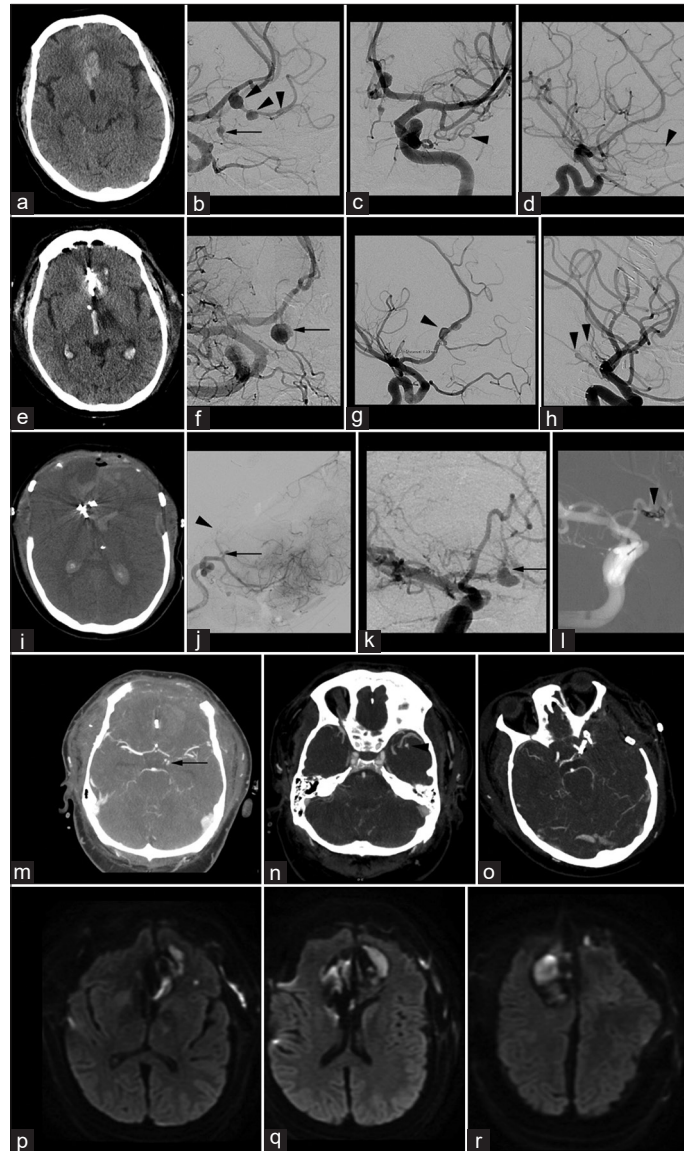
Depiction of the most relevant imaging findings from the patient's treatment. (a) Presentation CT head demonstrating left inferior frontal hemorrhage suspicious of vascular origin, (b-d) initial diagnostic DSA, (b) lateral view of the left ICA injection demonstrating $\times 1$ fusiform aneurysm on the orbitofrontal branch of the left ACA (arrow) and 3 fusiform aneurysms on the frontopolar branch of the left ACA (arrowheads), (c) AP view of the left ICA injection demonstrating fusiform aneurysm at the distal ATA of the left MCA (arrowhead), (d) lateral view of the right ICA injection demonstrating a fusiform aneurysm on the frontopolar branch of the right ACA (arrowhead), (e) CT scan obtained on postbleed day 4 and postoperative day 2 following parent vessel occlusion of the left frontopolar branch of the left ACA demonstrating new IVH and fresh blood in the inferior left frontal lobe suggesting re-bleed, (f-h) DSA obtained following re-bleeding on postbleed day 4, (f) oblique view of the left ICA injection demonstrating interval growth of the untreated left orbitofrontal branch fusiform aneurysm (arrow), (g) lateral view of the right ICA injection showing three new fusiform aneurysms on the A2 segment of the right ACA (arrowhead), (h) AP view of the left ICA injection showing new fusiform aneurysms of the distal AChA and PCOMA (arrowheads), (i and j) postbleed day 8 following further surgery with bilateral A2 occlusion and bifrontal decompression, (i) CT head demonstrating extensive bifrontal decompression and swelling following intraoperative sacrifice of bilateral A2s, (j) intraoperative DSA demonstrating no flow in the left ACA at the A2 segment (arrowhead) with new aneurysm formation at the ACOMA (arrow), (k-l) interval DSA on postbleed day 9, (k) AP injection of the right ICA demonstrating treating growth of the ACOMA aneurysm (arrow), (l) intraprocedural image on postbleed day 9 during parent vessel occlusion of the right A1 to treat the enlarging ACOMA aneurysm (arrowhead), (m) Interval imaging on postbleed day 10 demonstrating growth of the previously identified AChA and PCOMA aneurysms (arrow), (n) interval imaging on postbleed day 10 demonstrating stable ATA aneurysm, (o) postoperative CT head following pterional craniotomy and parent vessel occlusion of the growing AChA and PCOMA aneurysms and the stable ATA aneurysm, and (p-r) follow-up MRI 1 month following initial presentation demonstrating DWI lesions in both ACA territories, although not extensive and not encompassing the whole territories despite occlusion of both A2s and a DWI lesion in the left thalamus in keeping with hypodensities seen on presentation CT.
